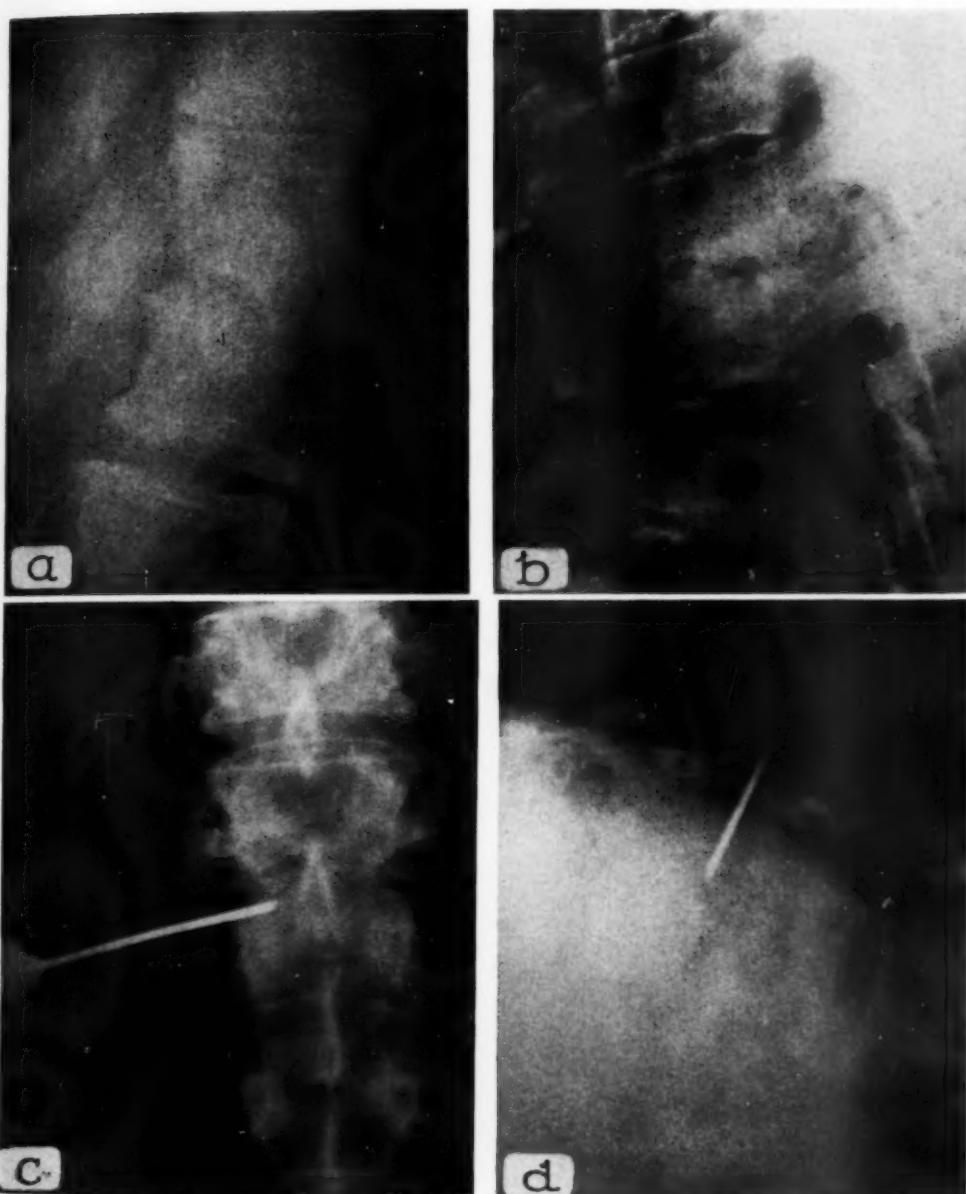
Case II. Roentgenogram made March 12, 1950, showing osteomyelitis at the L1-2 (a) and D7-8 (b) levels. Aspiration was carried out, using a Biers 15-gauge spinal needle (c and d).
